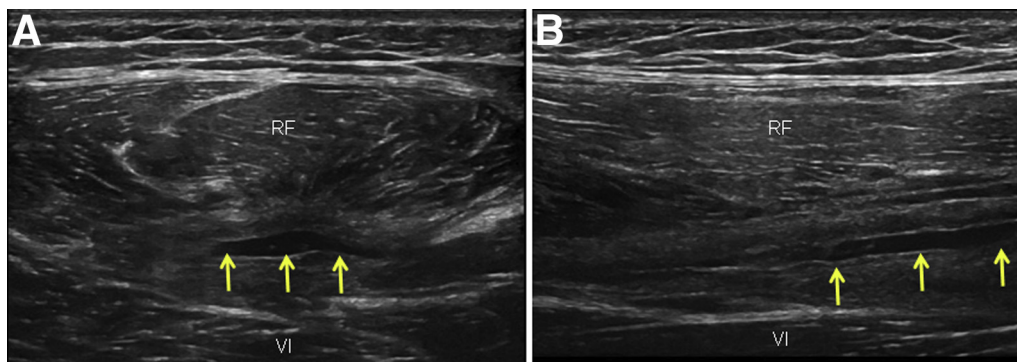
Postoperative ultrasound evaluation of the hematoma. (A) Short-axis view of residual hematoma (yellow arrows), rectus femoris (RF), and vastus intermedius (VI). Almost all of the hematoma was evacuated. (B) Long-axis view of residual hematoma (yellow arrows), RF, and VI. Almost all of the hematoma was evacuated.
